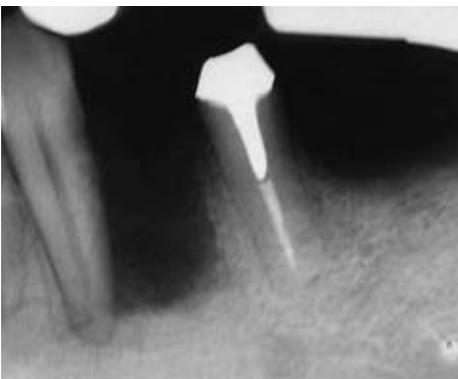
Radiograph 1 week postoperatively.
